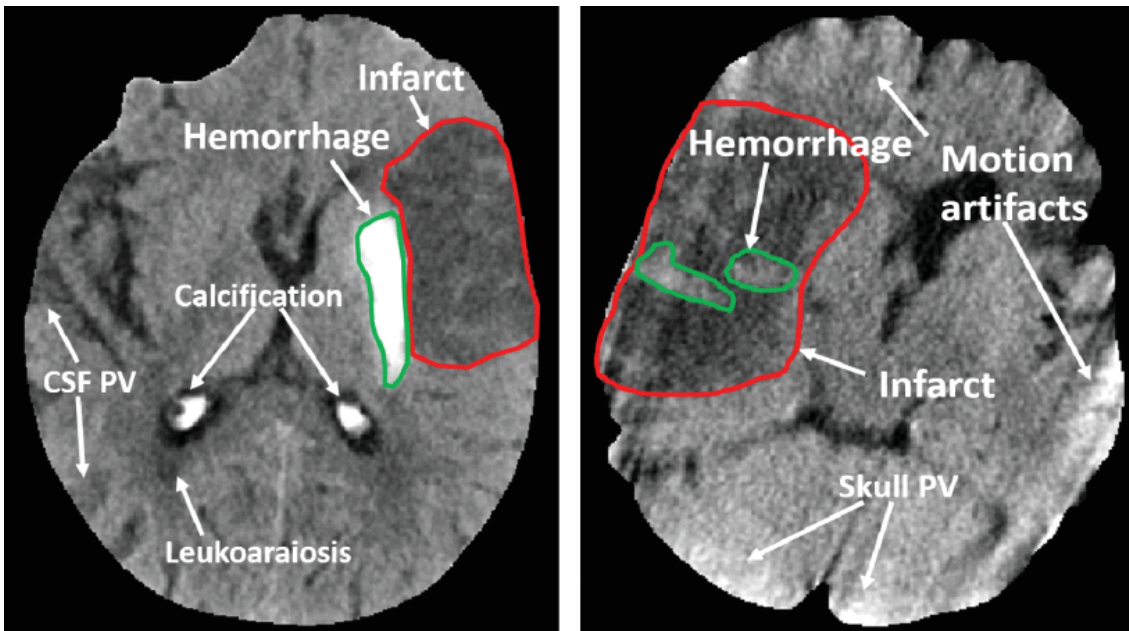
Samples of CT slices to depict *overlapping infarcts* – infarcts of multiple types at the same image region.
